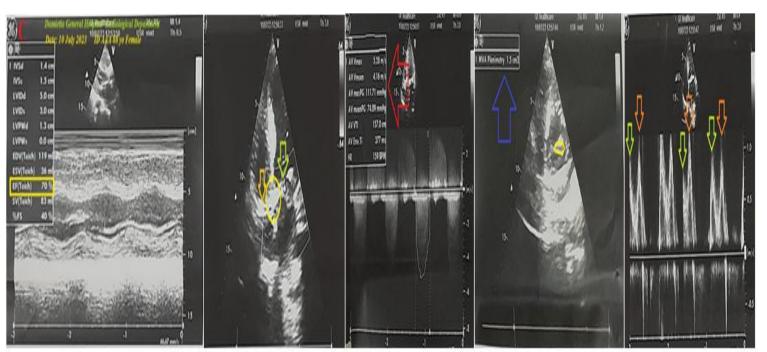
Echocardiography was done on the fourth day of ICU admission showing severe aortic stenosis (red arrow and central yellow circle), severe mitral stenosis (blue arrow, lime arrow, and ovoid yellow circle), mild tricuspid stenosis, (golden arrow), and diastolic dysfunction (orange and lime arrows) with normal EF (yellow rectangle).
